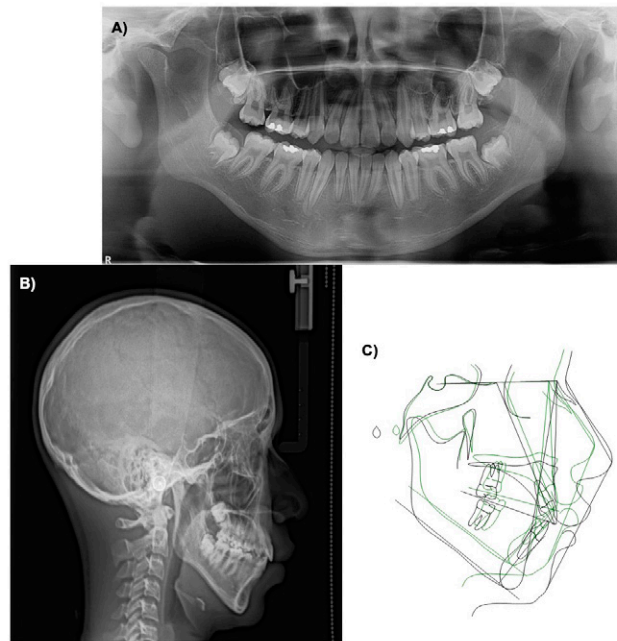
Final imaging studies. A) Orthopantomography. B) Lateral head film. C) Superimposition with Steiner tracing.
